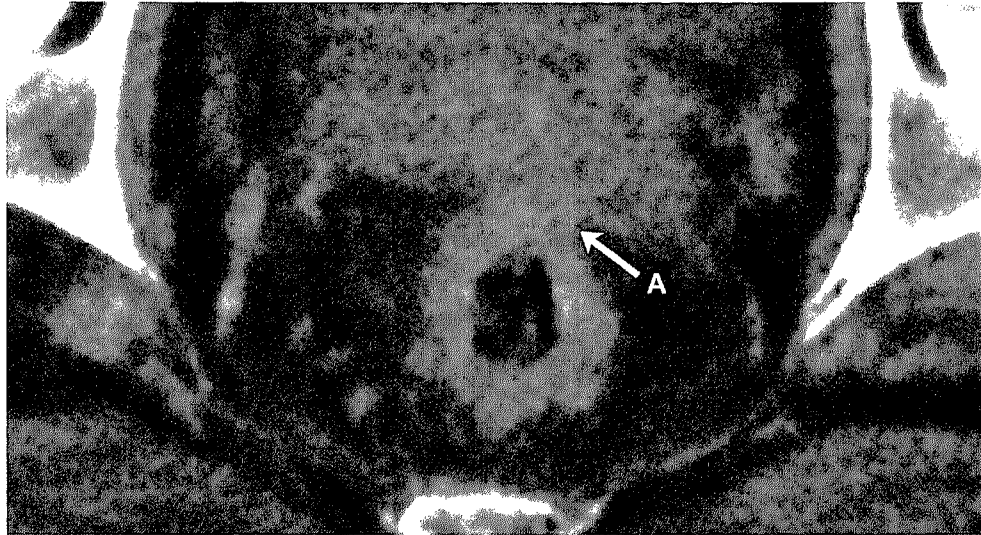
Axial contrast enhanced CT shows a locally advanced rectal cancer invading the mesorectal fascia and the seminal vesicles (A).
